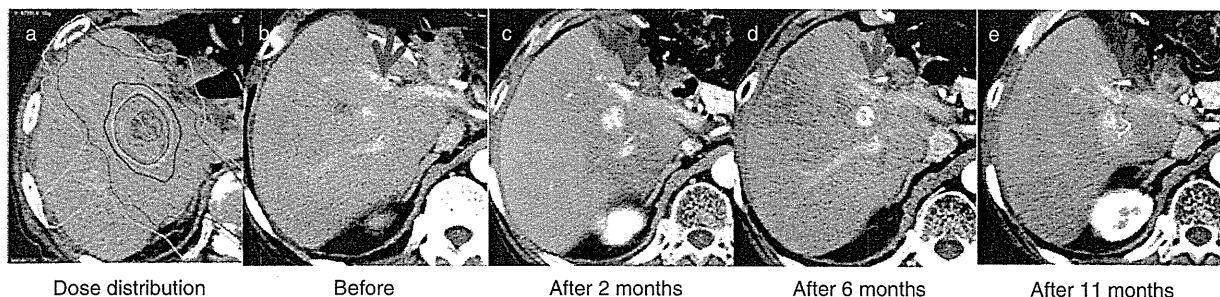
Dynamic computed tomographic appearance of tumor responses (arterial phase). (a) Dose distribution (48 Gy/4 fractions). (b) Before stereotactic body radiotherapy (SBRT), early arterial enhancement is visible (red arrow). (c) After two and (d) after 6 months, early arterial enhancement is more evident than before stereotactic body radiotherapy (red arrow). (e) After 11 months, enhancement remains, although the tumor is shrinking (red arrow).
